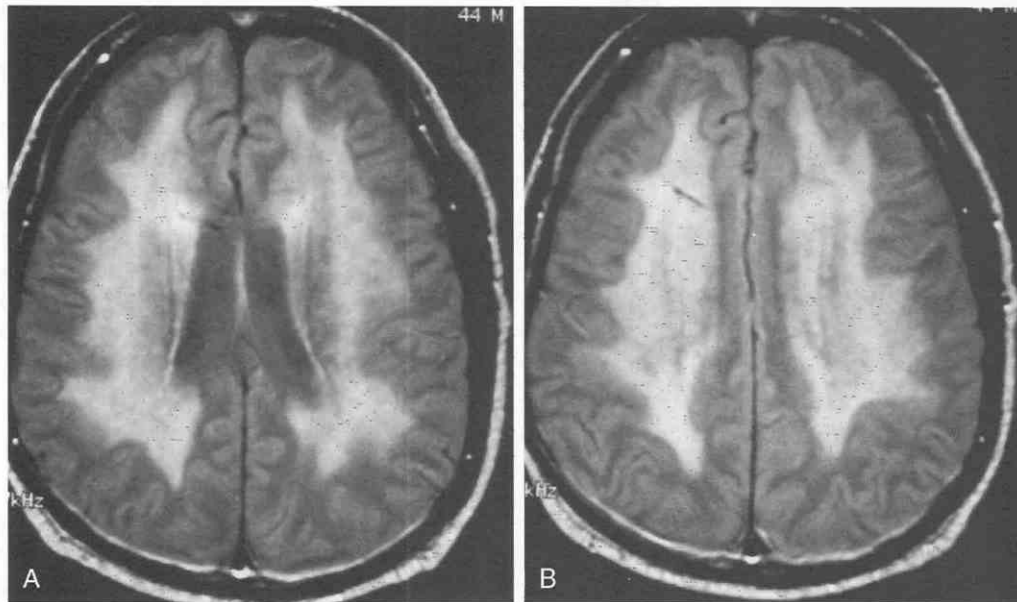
Leukoencephalopathy secondary to radiation and intraventricular methotrexate chemotherapy. A and B, Proton-density axial cranial MR image. There is extensive diffuse, confluent white matter hyperintensity.
